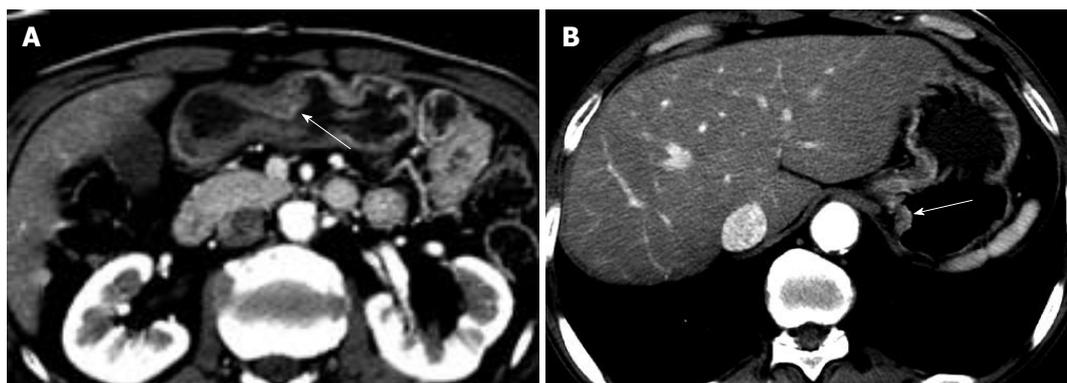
Early gastric cancer in a 62-year-old man. The size of tumor was 2.2 cm at the longest diameter and the tumor extended to submucosal layer. A: The transverse computed tomography scan shows thickened wall with enhancement in greater curvature of gastric antrum (arrow), which was true lesion based on gastroscopy and pathologic examination; B: Reviewer 1 indicated a lesion (arrow) as a cancer focus because thickened wall was suspicious on blinded analysis. However, on unblinded analysis, focal lesion (arrow) in greater curvature of gastric antrum in lower gastric 1/3 segment was indicated correctly.
